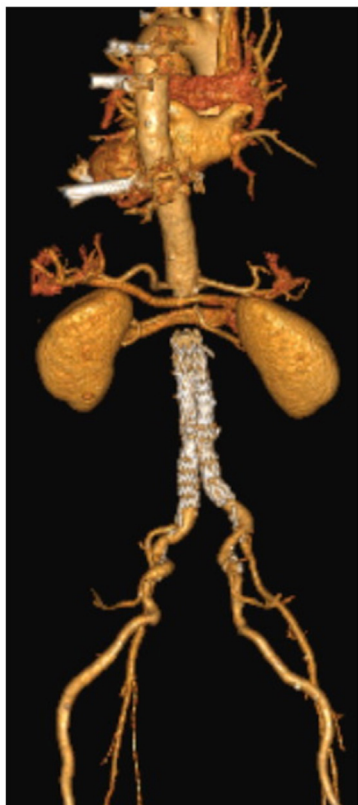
Three-dimensional reconstruction of computed tomography angiogram (CTA) showing adequate endovascular treatment of the abdominal aortic aneurysm (AAA) with an ultra-low profile endograft: anterior view.
